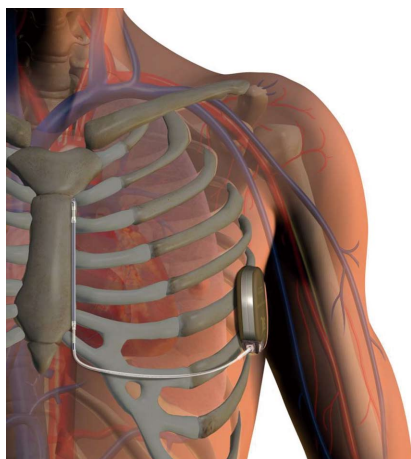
The subcutaneous implantable cardioverter-defibrillator system with the pulse generator implanted subcutaneously in a left lateral position, and the parasternal lead-electrode positioned parallel to and 1 to 2 cm to the left of the sternal midline. The lead-electrode contains two sensing electrodes separated by an 8 cm shocking coil.
